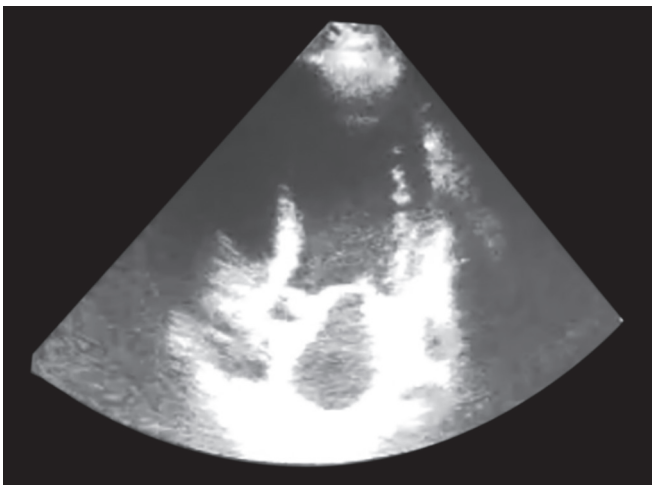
2D echo—parasternal short axis view showing hypokinetic LV
